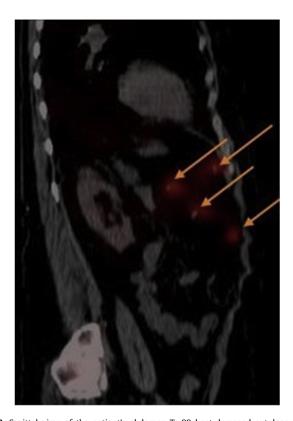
Sagittal view of the patient's abdomen Tc-99 heat-damaged autologous red blood cell scan SPECT/CT. The scan shows uniform uptake of Tc-99 heat-damaged autologous red blood cells in the previously identified intraperitoneal masses (orange arrows), indicating splenic origin.
